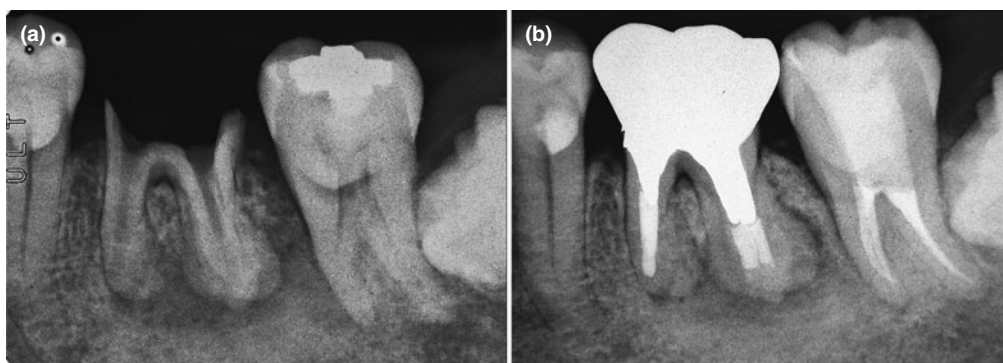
Case 2: (a) Preoperative radiograph of lower left first and second molars showing contiguous apical bone lesions. (b) Radiograph taken at recall 2 years later showing reduction in size of lesions.
